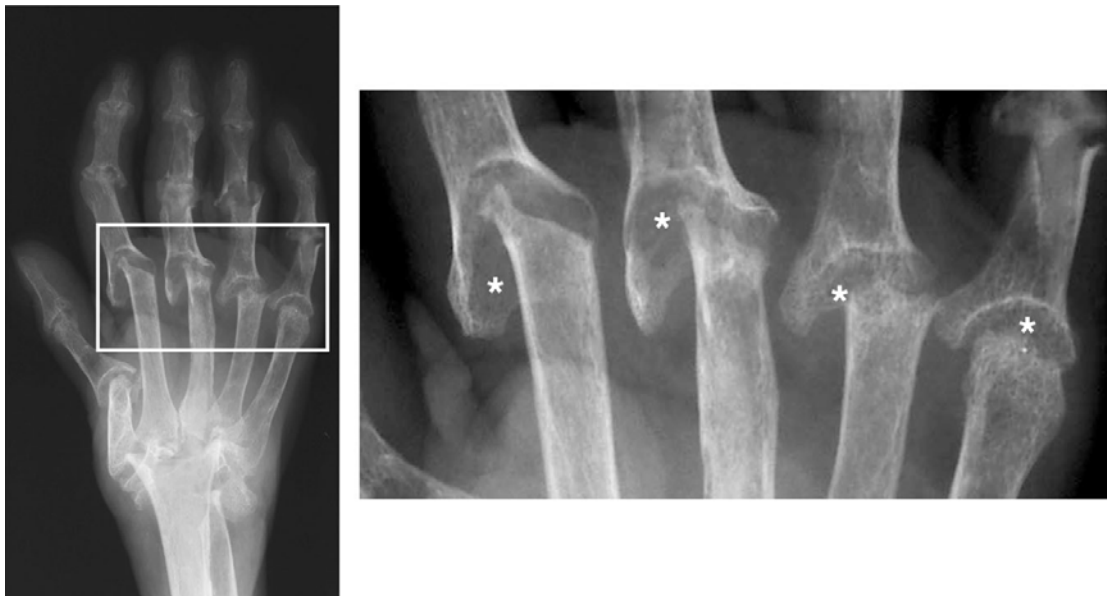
Radiograph of a hand with RA (177). Asterisks demonstrate areas of bone erosion.
